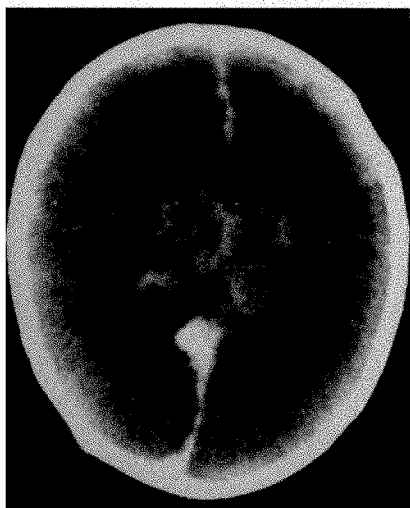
Computed tomographic scan of patient 1, without contrast, showing a posterior ossa interhemispheric subdural hematoma with subarachnoid hemorrhage and massive cerebral edema with more mass effect on the right than the left, with a midline shift.
